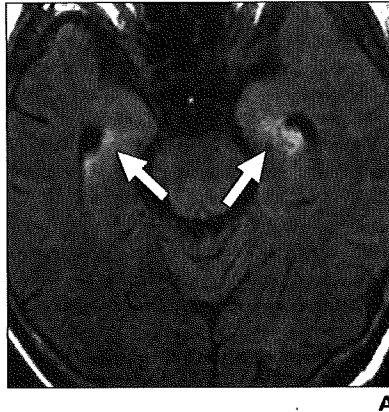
57-year-old man with nonherpetic limbic encephalitis had short-term memory loss on 25th day after hematopoietic stem cell transplantation (HSCT). Abnormal signals on FLAIR MR images persisted through follow-up period.
